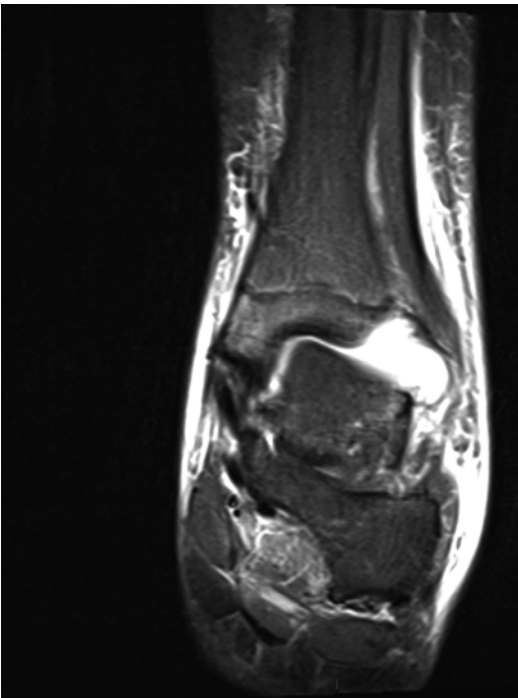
MRI of septic arthritis of the ankle showing an effusion
